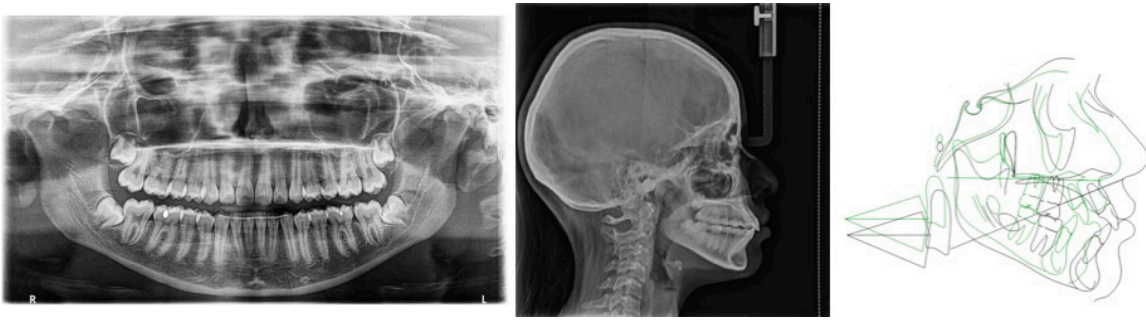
Final orthopantomography and lateral headfilm, and superimposition image.
